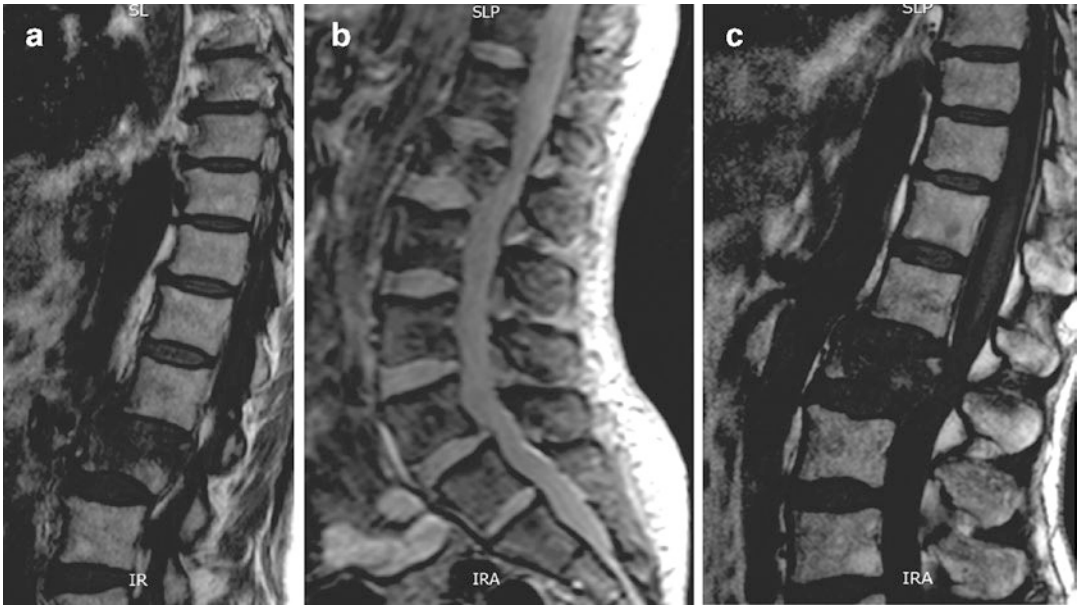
(a) T1 parasagittal MRI of the spine. (b) T2 parasagittal MRI of the spine. (c) Parasagittal MRI of the spine
